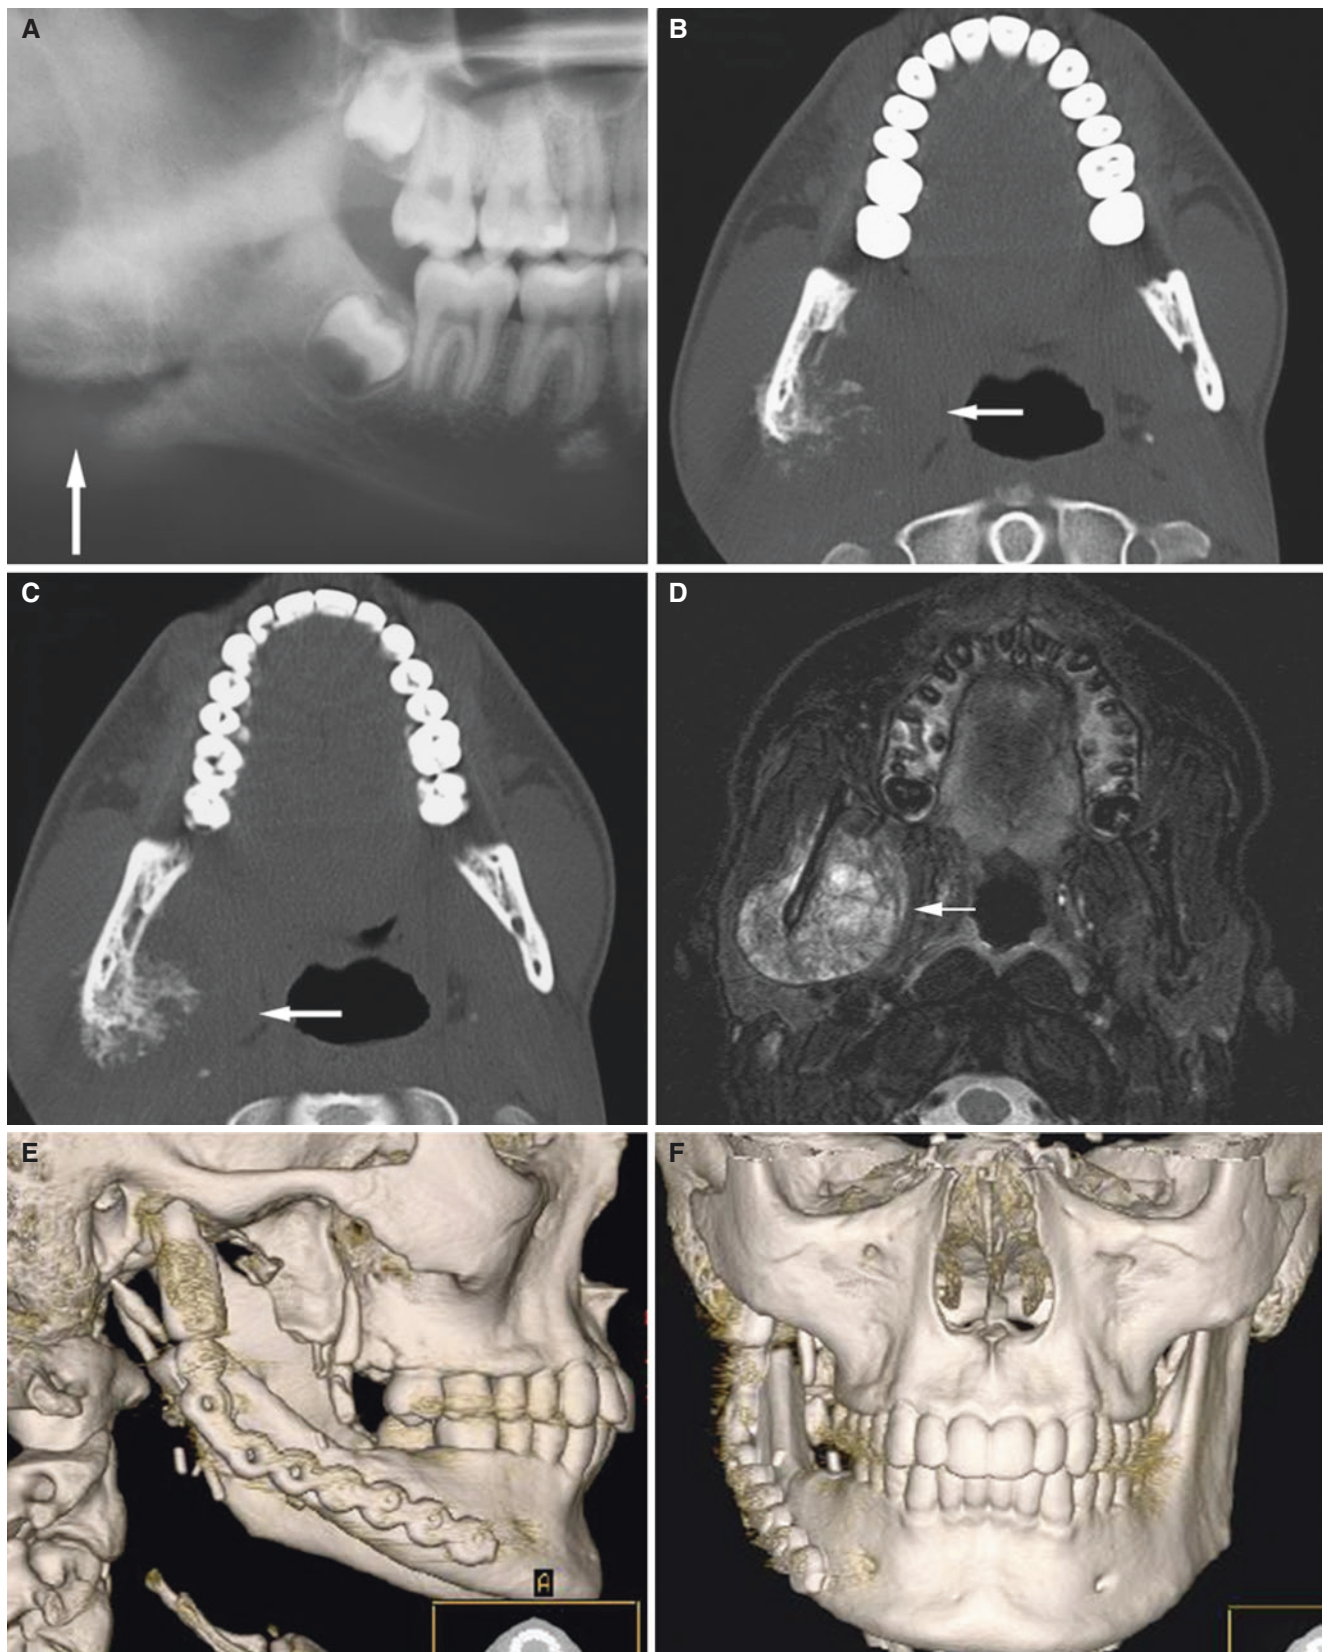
Osteosarcoma, mandible; 16-year-old male with painless buccal swelling at the right mandibular angle. (A) Panoramic view shows diffuse bone mass (*arrow*). (B) Axial CT image shows bone production radiating from ramus, predominantly on lingual side (*arrow*). (C) Axial CT image shows more extensive bone production
